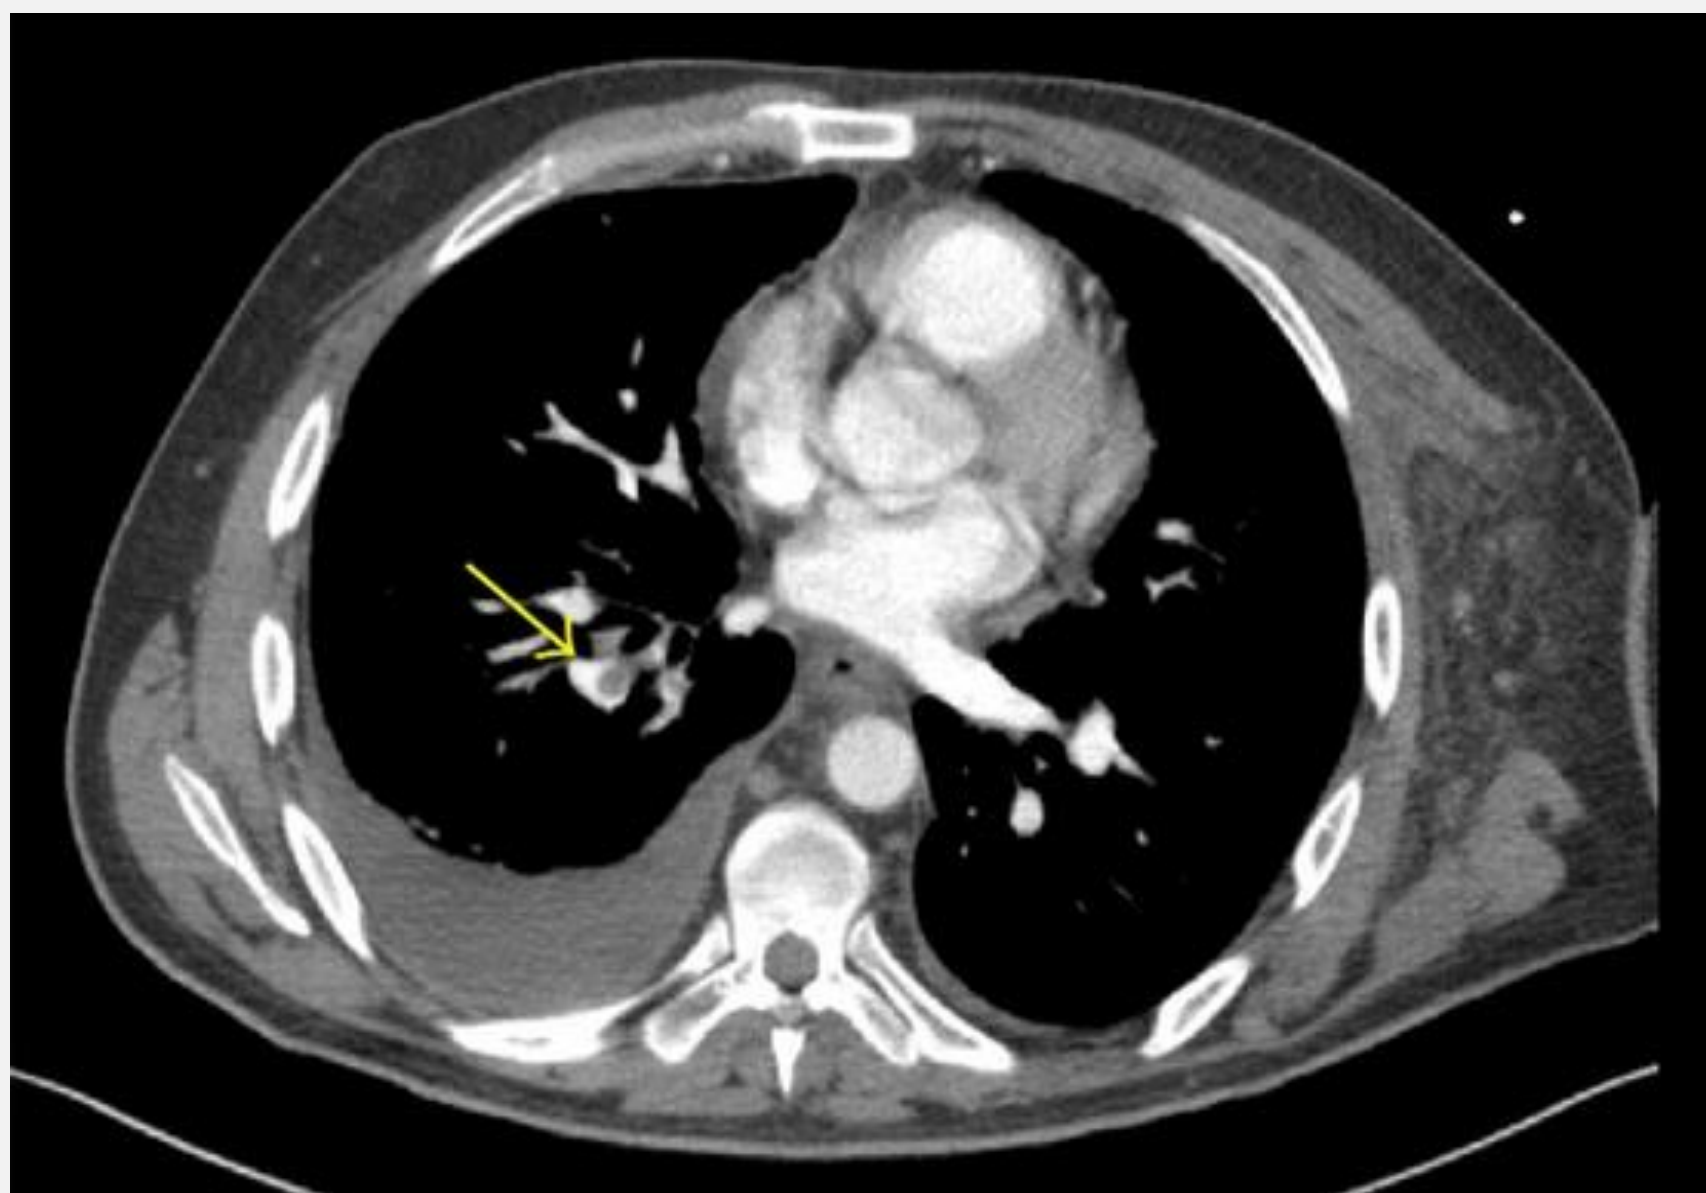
CT Chest with right segmental PE
